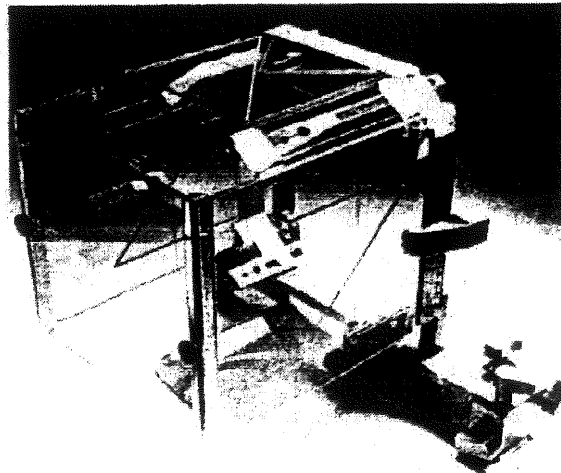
Leksell Coordinate Frame, Localizer Frame, and CT Adapter [16].
